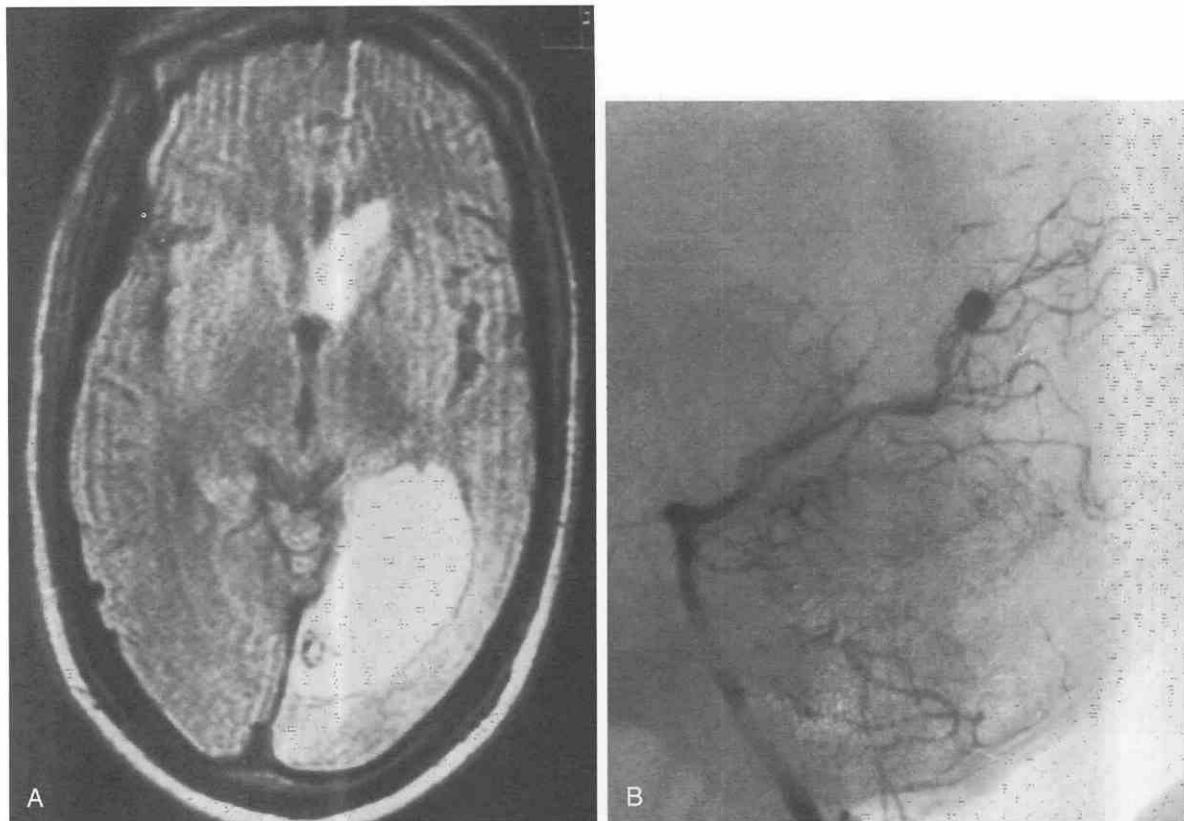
Mycotic aneurysm. *A*, Proton-density-weighted image shows high-signal-intensity hemorrhage in the left occipital lobe as well as in the ventricle. A small, ringlike, low-signal-intensity area is seen within the hemorrhage. *B*, A mycotic aneurysm was found on cerebral angiogram, corresponding to the small, ringlike, low-signal-intensity area seen on the MRI study.
